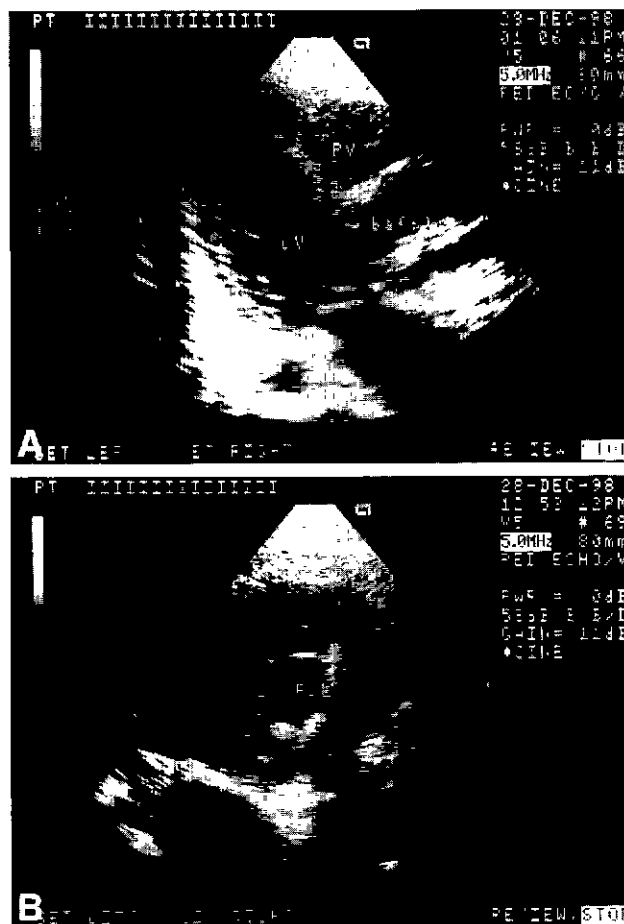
Postoperative transthoracic echocardiographic view of the left ventricular outflow tract demonstrating unobstructive intraventricular rerouting tunnel (A) long-axis view, (B) cross-section view.
